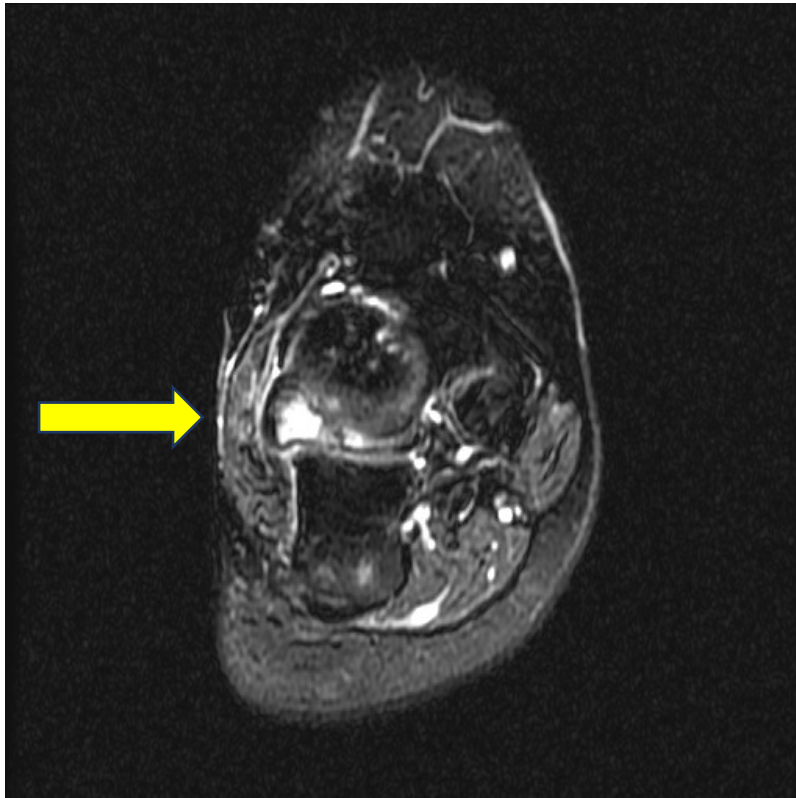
May 20, 2016 right ankle MRI: osteochondral fragment over the calcaneonavicular junction. Adjacent bone sclerosis and edema
